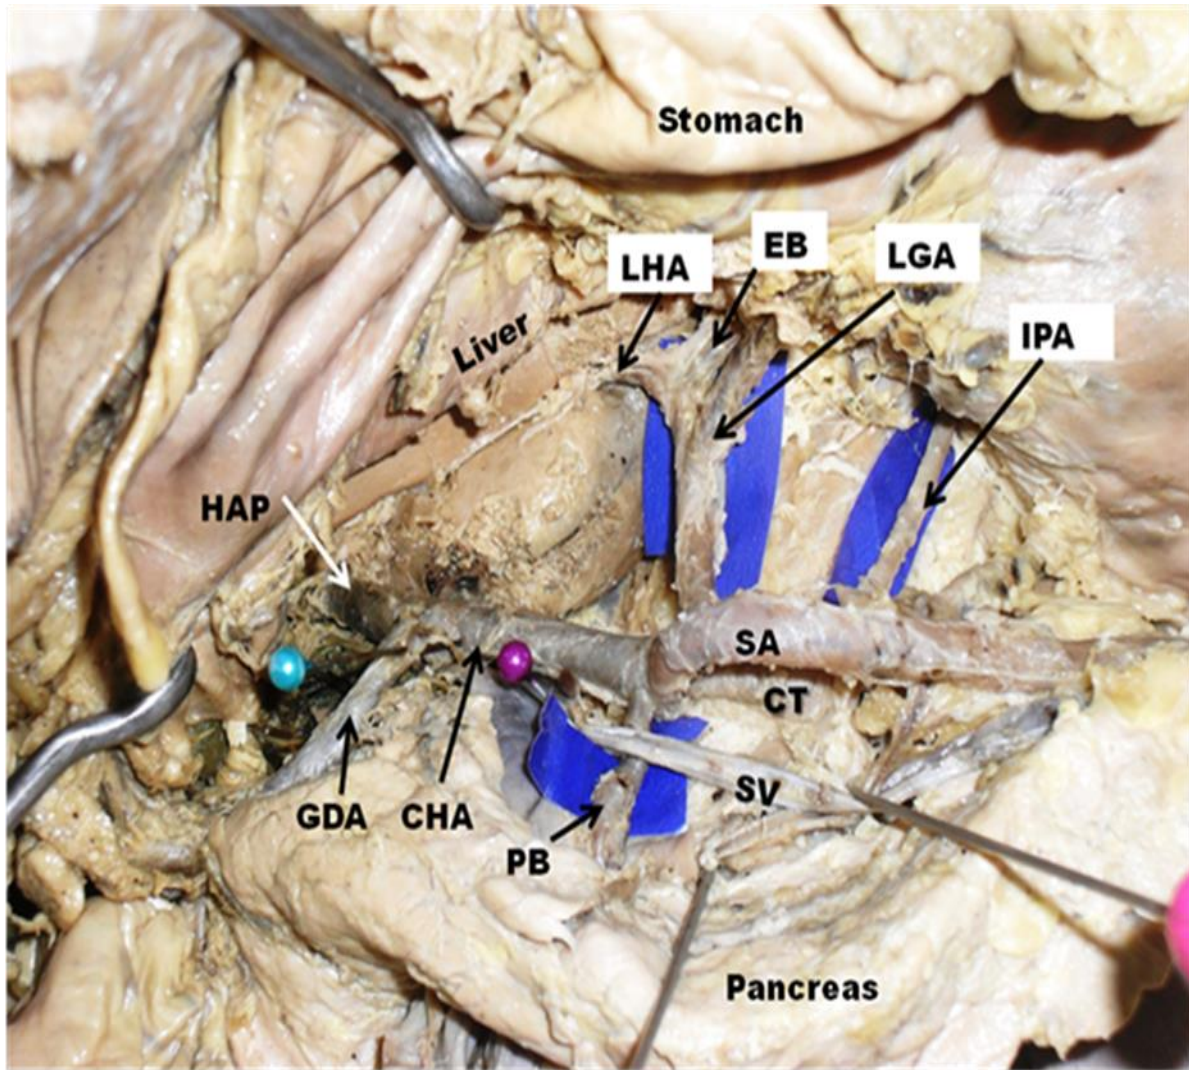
Closer view of anomalous branching pattern of celiac trunk (CT) giving rise to pancreatic branch (PB) passing behind the splenic vein (SV) and supplying the retracted pancreas, Left hepatic artery (LHA) and esophageal branch (EB) arising from left gastric artery (LGA) and undivided hepatic artery proper (HAP) continuing as right hepatic artery. CHA- common hepatic artery, GDA-gastroduodenal artery, IPA-inferior phrenic artery. SA- splenic artery
